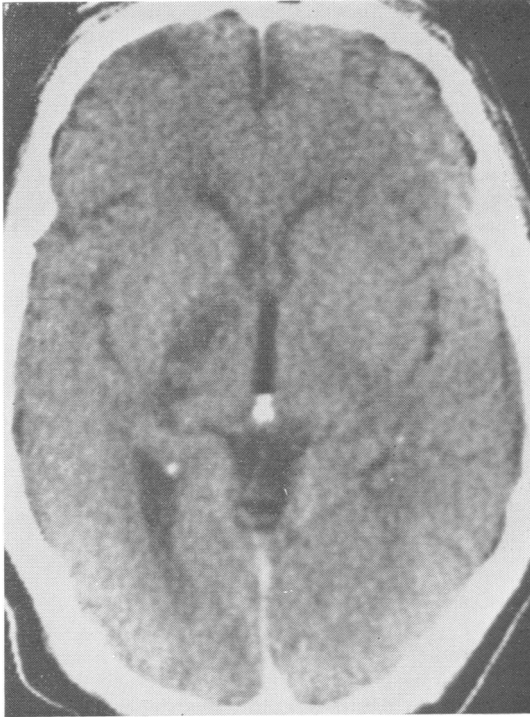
CT scan of patient 1 performed 7 days after onset of symptoms.
